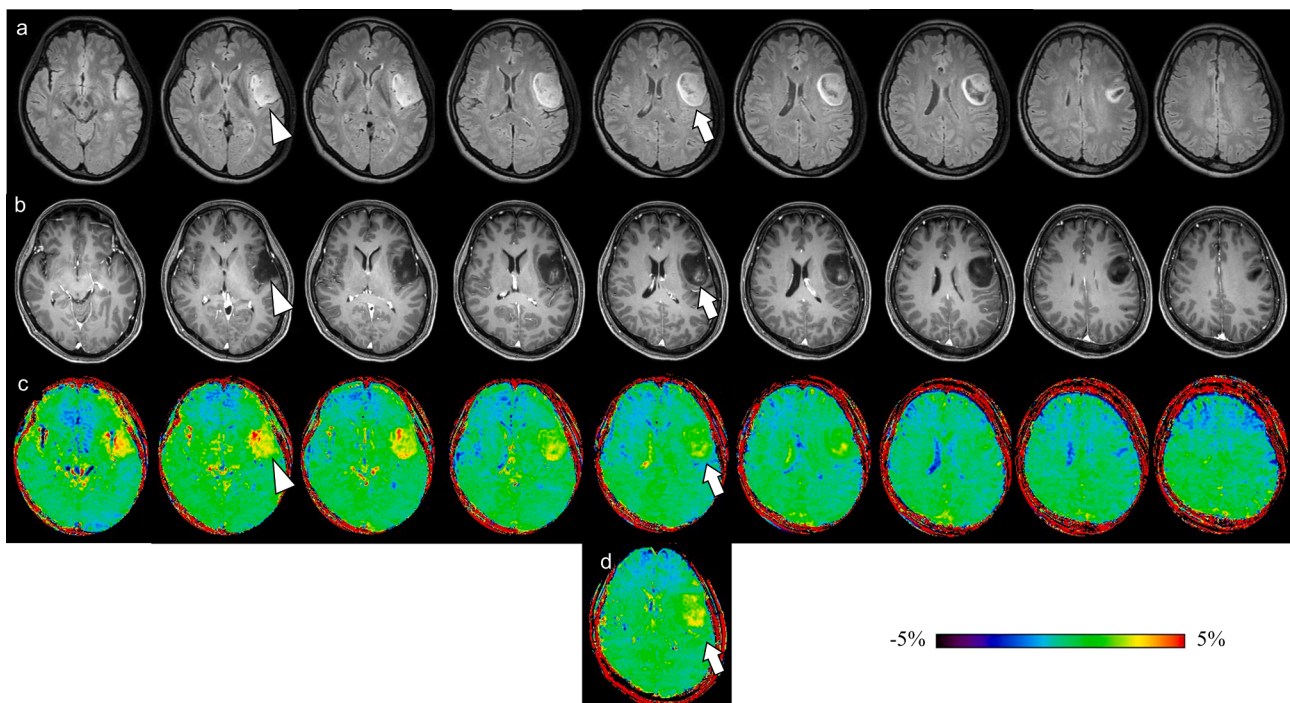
Astrocytoma, IDH-mutant, CNS WHO grade 3 in a 50-year-old female. (a) FLAIR, (b) Gd T1WI, (c) 3D MTRasym at 3.5 ppm, and (d) 2D MTRasym at 3.5 ppm. The MTRasym at 3.5 ppm for the 2D (arrow), 3D_{all}, and 3D_{max} (arrowhead) methods were 2.20 ± 0.60 , 2.00 ± 1.06 , and 2.80 ± 0.80 , respectively. Both the 2D MTRasym at 3.5 ppm and the 3D MTRasym at 3.5 ppm showed a mild increase in signal intensity in the lesion with contrast enhancement (arrows in b–d). However, the signal intensity varied depending on the slice position, and the 2D MTRasym at 3.5 ppm image (d) was not the same slice position as that for the 3D_{max} (c, arrowhead).
